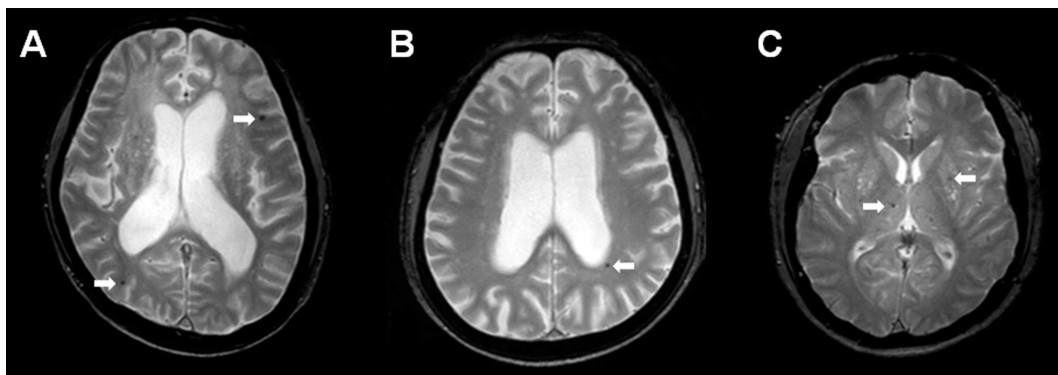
Axial MRI obtained with conventional 2D T2*-weighted GRE sequences. MRI from a patient with Parkinson's disease (PD)-dementia exhibits multiple cerebral microbleeds (CMBs) in the right occipital lobe and left frontal lobe (A). MRI from a patient with PD-mild cognitive impairment shows a right periventricular CMB (B), and MRI from a patient with PD-cognitively normal shows bilateral thalamic and basal ganglia CMBs (C).
